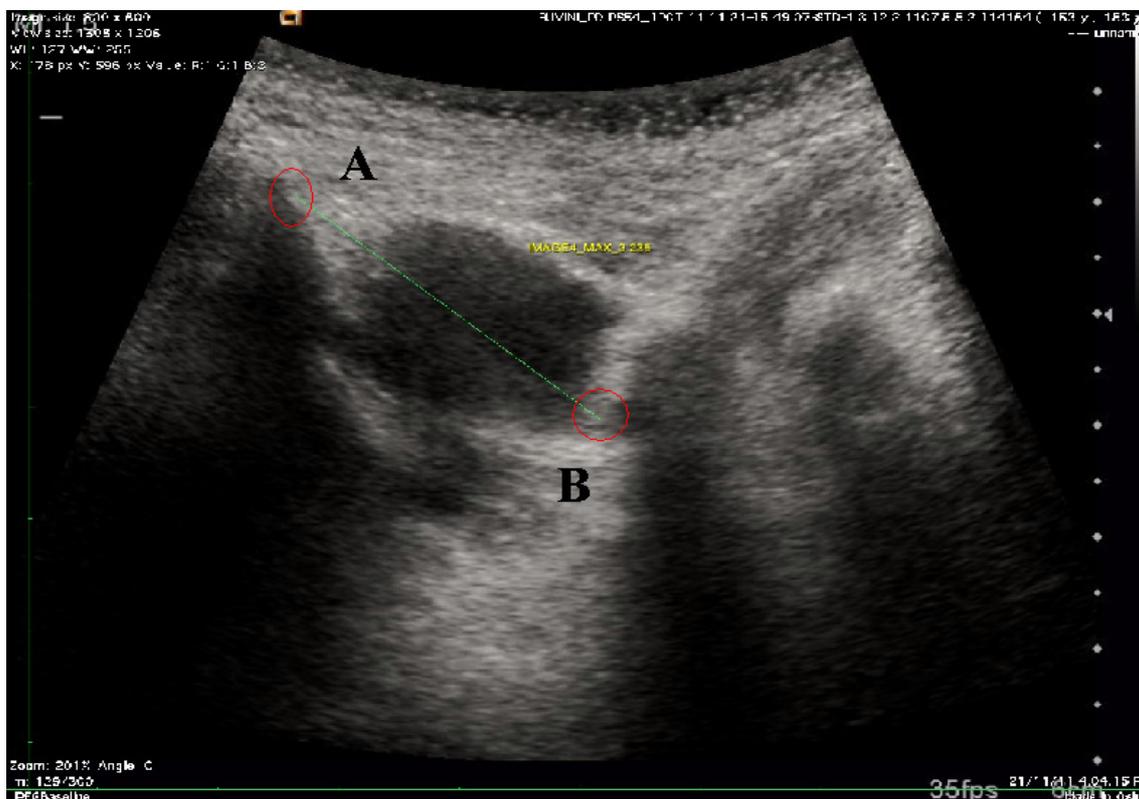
B mode ultrasound image of the hyoid and spine of mandible distance at the point of maximal displacement. The caliper mark at the mental spine of the mandible (A) and the caliper at the hyoid shadow (B). This has shifted anteriorly toward the mental spine of the mandible.
